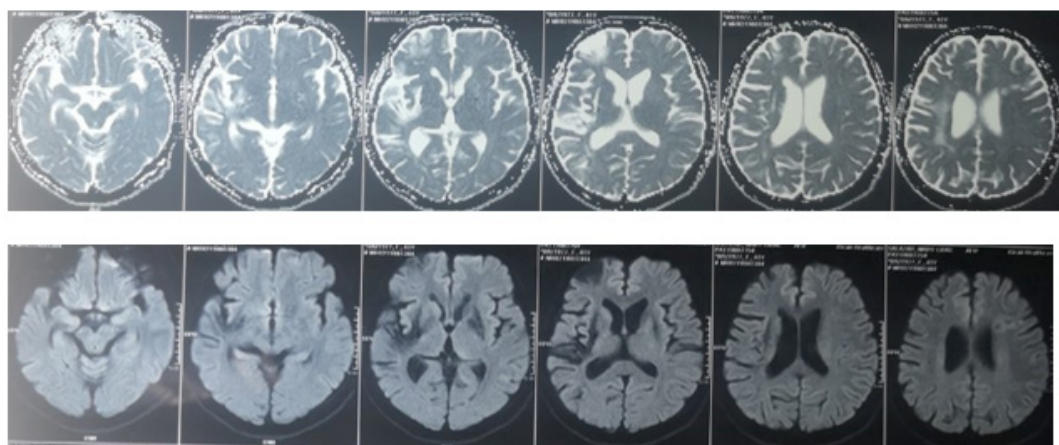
Cranial MRI with contrast DWI and ADC sequences.
